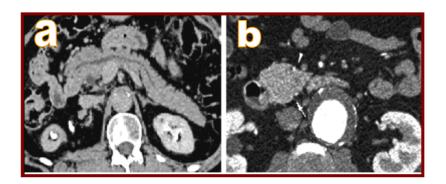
Normal CT anatomy of the pancreas:
